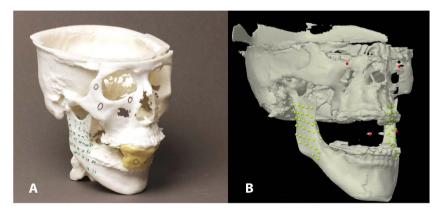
Printed skull models with fixed mandibles were prepared with radiopaque gutta-percha points. Measurement points were inserted in the mandibular angle and the oblique line bilaterally, and hard tissue peri-orbital and splint-based occlusal landmark registration points were added (A). The measurement points (green) and registration points (red) were marked digitally on the cone beam computed tomography image (B).
